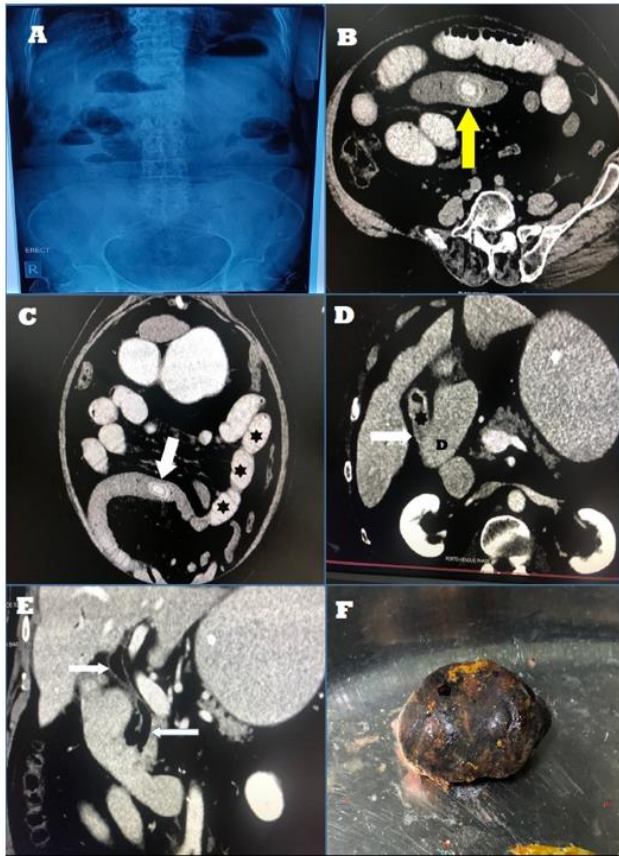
(A) Plain X-ray abdo shows multiple air-fluid levels in classical step-ladder pattern; (B) CECT abdo pics-axial view showing the large lamellated stone (yellow arrow) in the terminal ileum; (C) coronal view showing the obstructing gall stone in ileum (white arrow) with the dilated proximal contrast filled small bowel loops (black asterisks); (D) axial view showing the cholecysto-duodenal fistula (white arrow) betn the GB (black asterisk) and duodenum (black 'D'); (E) coronal view showing pneumobilia (white arrows); and (F) the retrieved culprit.
